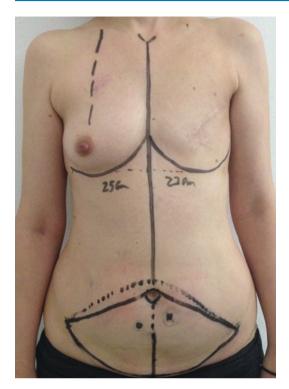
Female patient that underwent skin-sparing mastectomy of the left breast, followed by radiation therapy. Two years after, she developed chronic RD with marked atrophy and telangiectasia. DIEP flap was scheduled for an autologous delayed breast reconstruction, and deep inferior epigastric perforators patency was assessed with CT angiography
